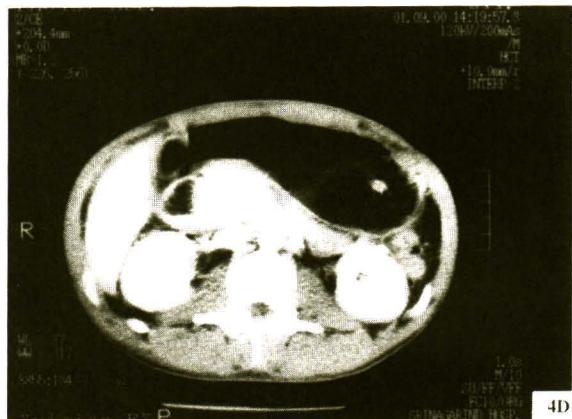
Enhanced CT scan on portovenous phase: This image shows an intramural hematoma causing dilatation of the duodenum evidenced by retained fluid filled in the lumen, marked by eccentric focus of fluid and compressed anteriorly by an intramural hematoma.
